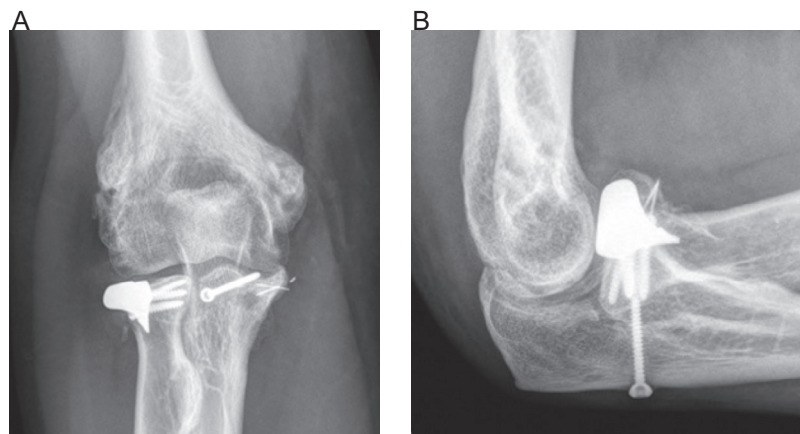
(A) Anteroposterior and (B) lateral radiographs of the right elbow 13 years postoperatively. Post-traumatic arthritic change is present in the elbow joint, but the implant itself demonstrates full bony ingrowth and no evidence of osteolysis or hardware failure. (Used with permission of Mayo Foundation for Medical Education and Research. All rights reserved.)
